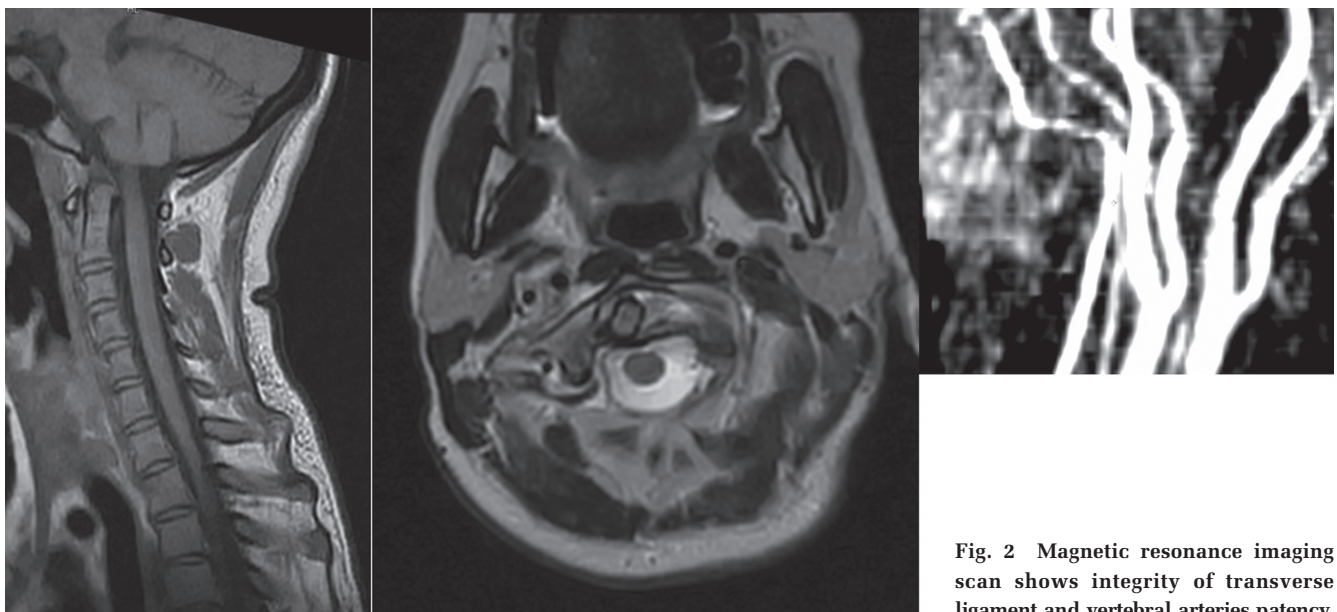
Magnetic resonance imaging scan shows integrity of transverse ligament and vertebral arteries patency.
